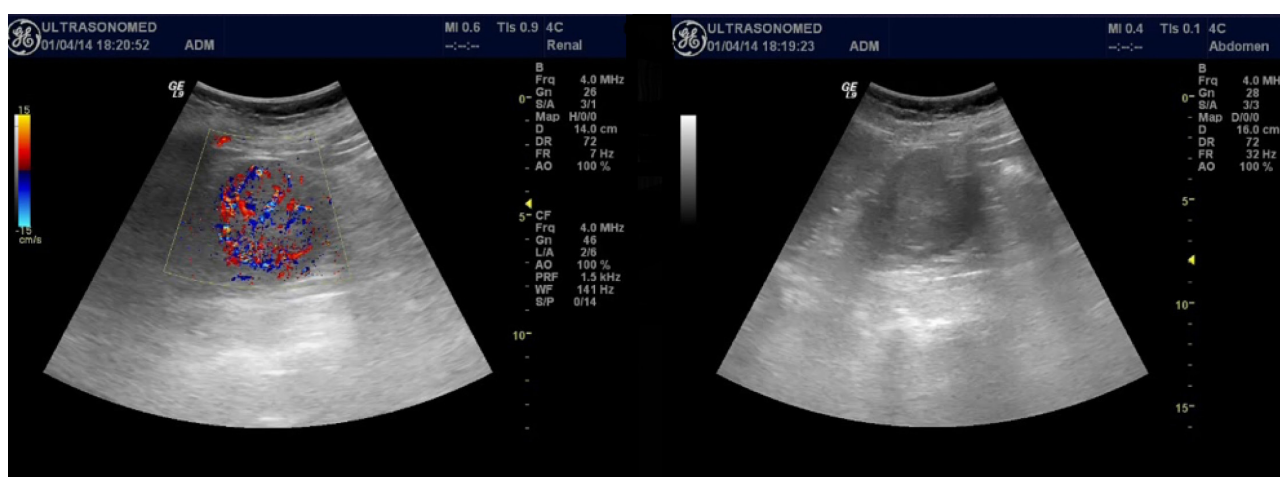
Ultrasound examination of the renal tumor, showing Doppler signal specific for renal carcinoma.
